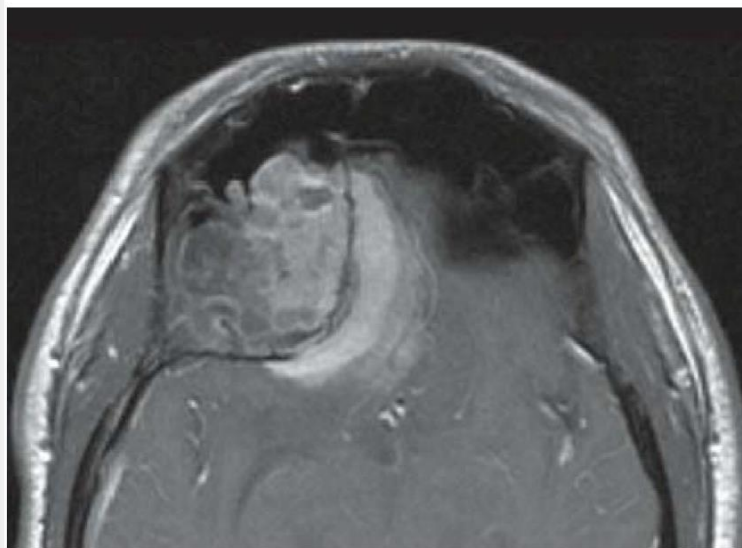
GFR Axial postcontrast T1-weighted MRI of the same patient shown in Figure 37.4 demonstrates enhancement within the granulomatous mass and the adjacent involved brain. Image and caption: Jeffrey Bennett, MD. Department of Radiology, University of Florida College of Medicine, Gainesville, FL.
